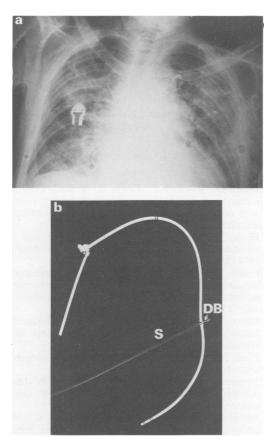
(a) Chest radiograph showing doubly knotted Swan-Ganz catheter; (\uparrow) (b) knotted catheter ensnared in Dotter basket (DB) partially withdrawn into sheath (S) (as removed from femoral vein).
